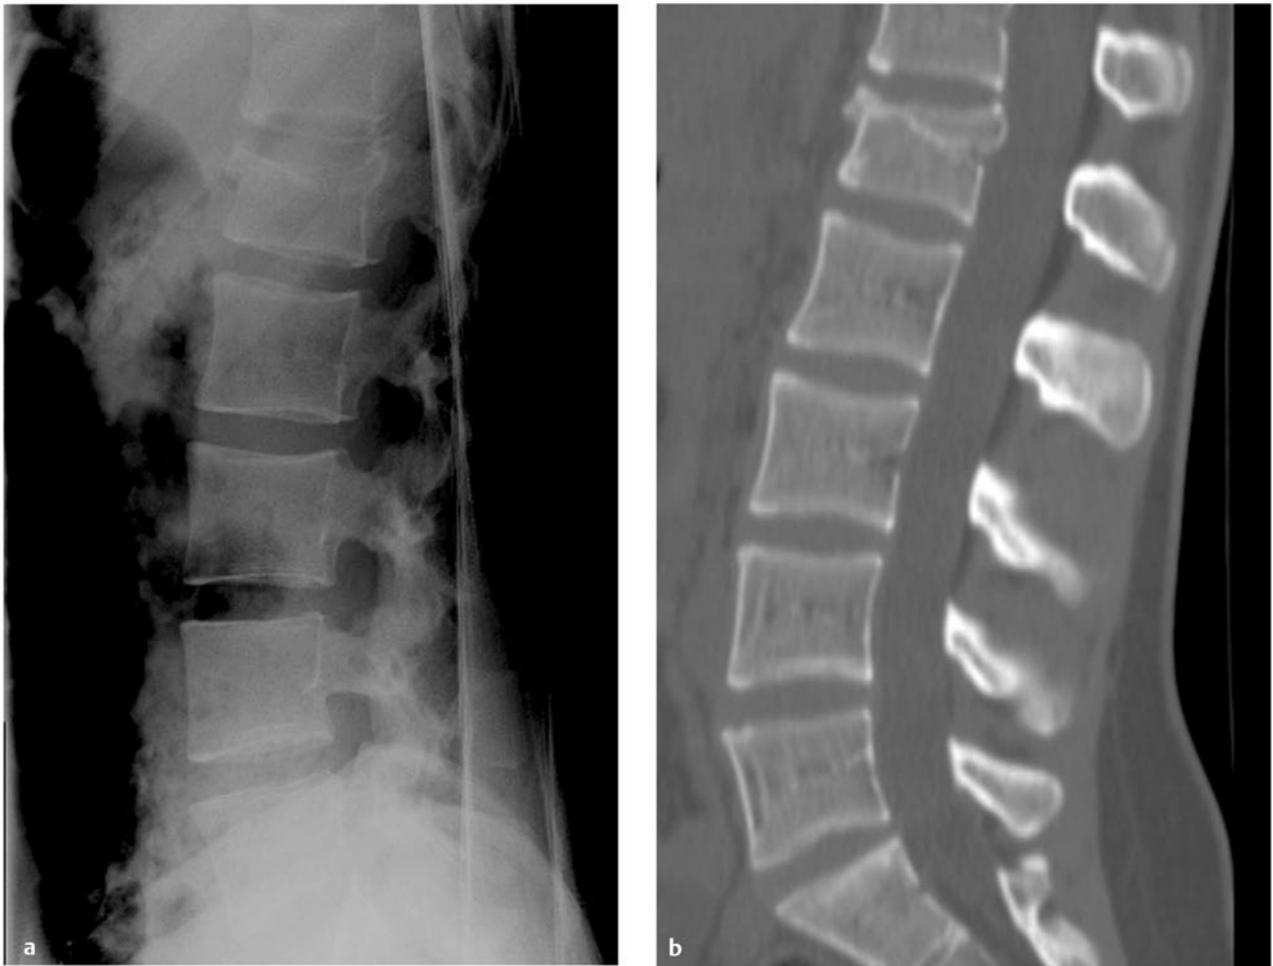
L1 compression (anterior wedge) fracture. (a) Lateral radiograph and (b) sagittal computed tomographic scan demonstrating a nonoperative compression fracture of L1 in a neurologically intact young girl. Note the lack of significant angulation or retropulsed bone fragments. Thoracolumbar compression fractures can often be treated conservatively. External immobilization may aid in pain control and prevent the development of deformity during fracture healing and remodeling.
